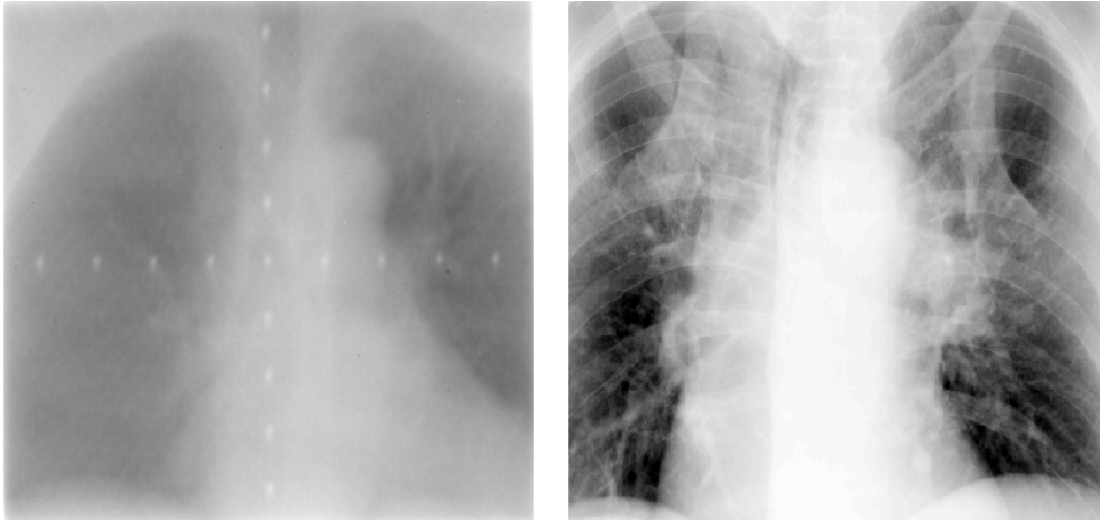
Comparison of anterior chest radiographs taken by MV portal imaging (left) and kV on-board imaging (right).
